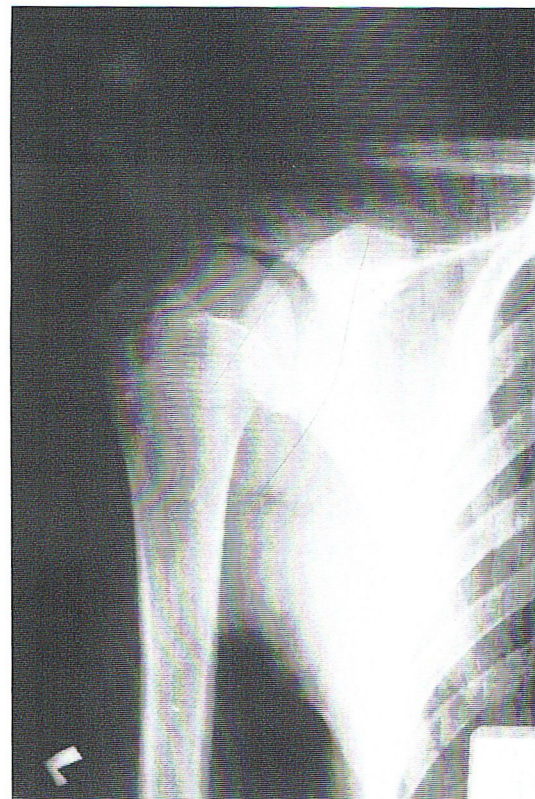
Shoulder joint X-rays: young girl
